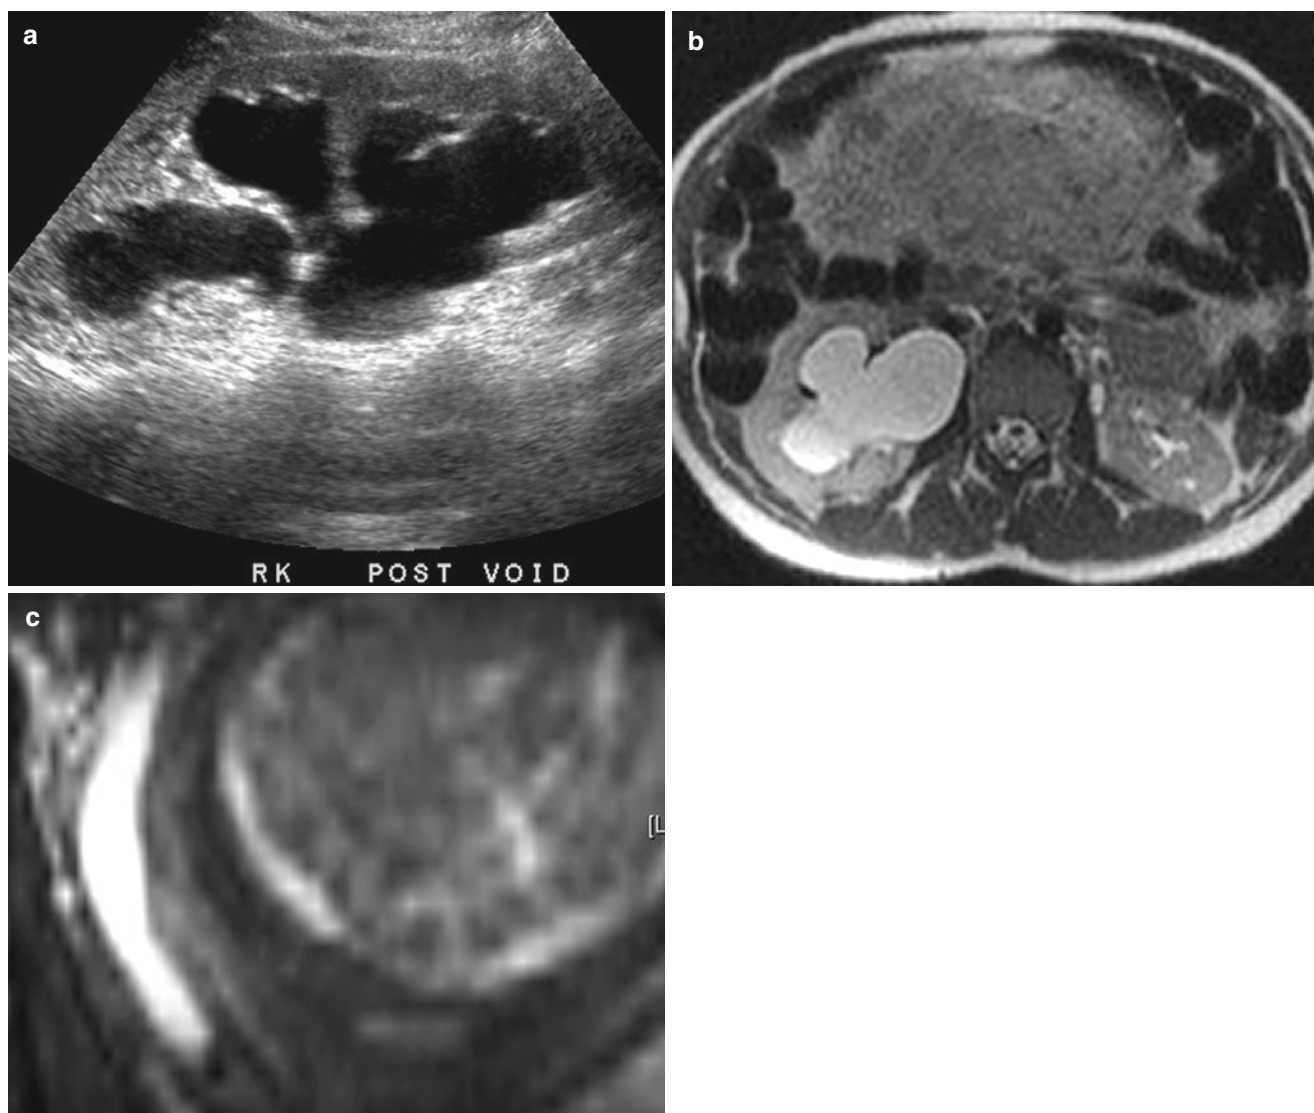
A 27-year-old female, 34 weeks pregnant, with right abdominal pain. (a) Ultrasound shows moderate right hydronephrosis. Distal right ureter not visualized and etiology was unclear. (b, c)
